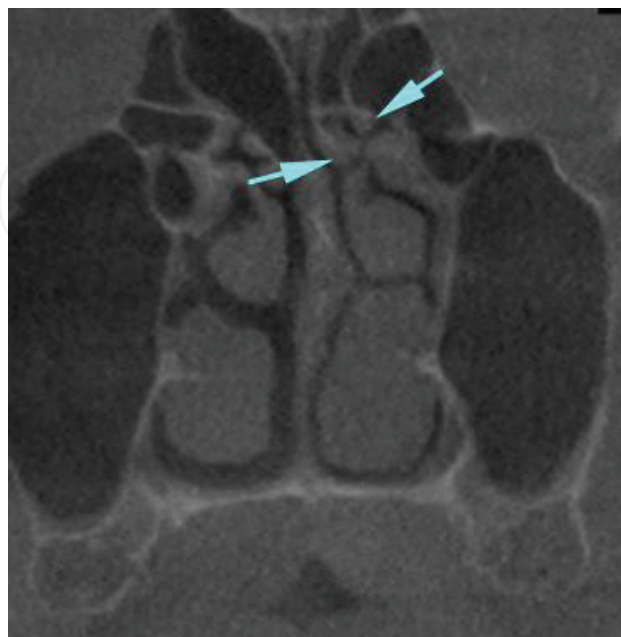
Coronal CBCT images showing the bifid superior turbinate.
